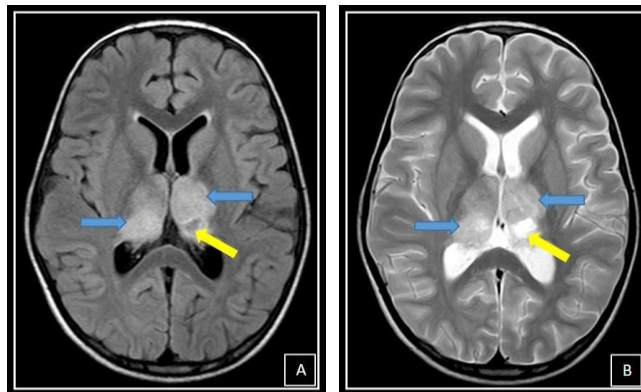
Influenza Encephalitis A: FLAIR axial B: T2 axial.
